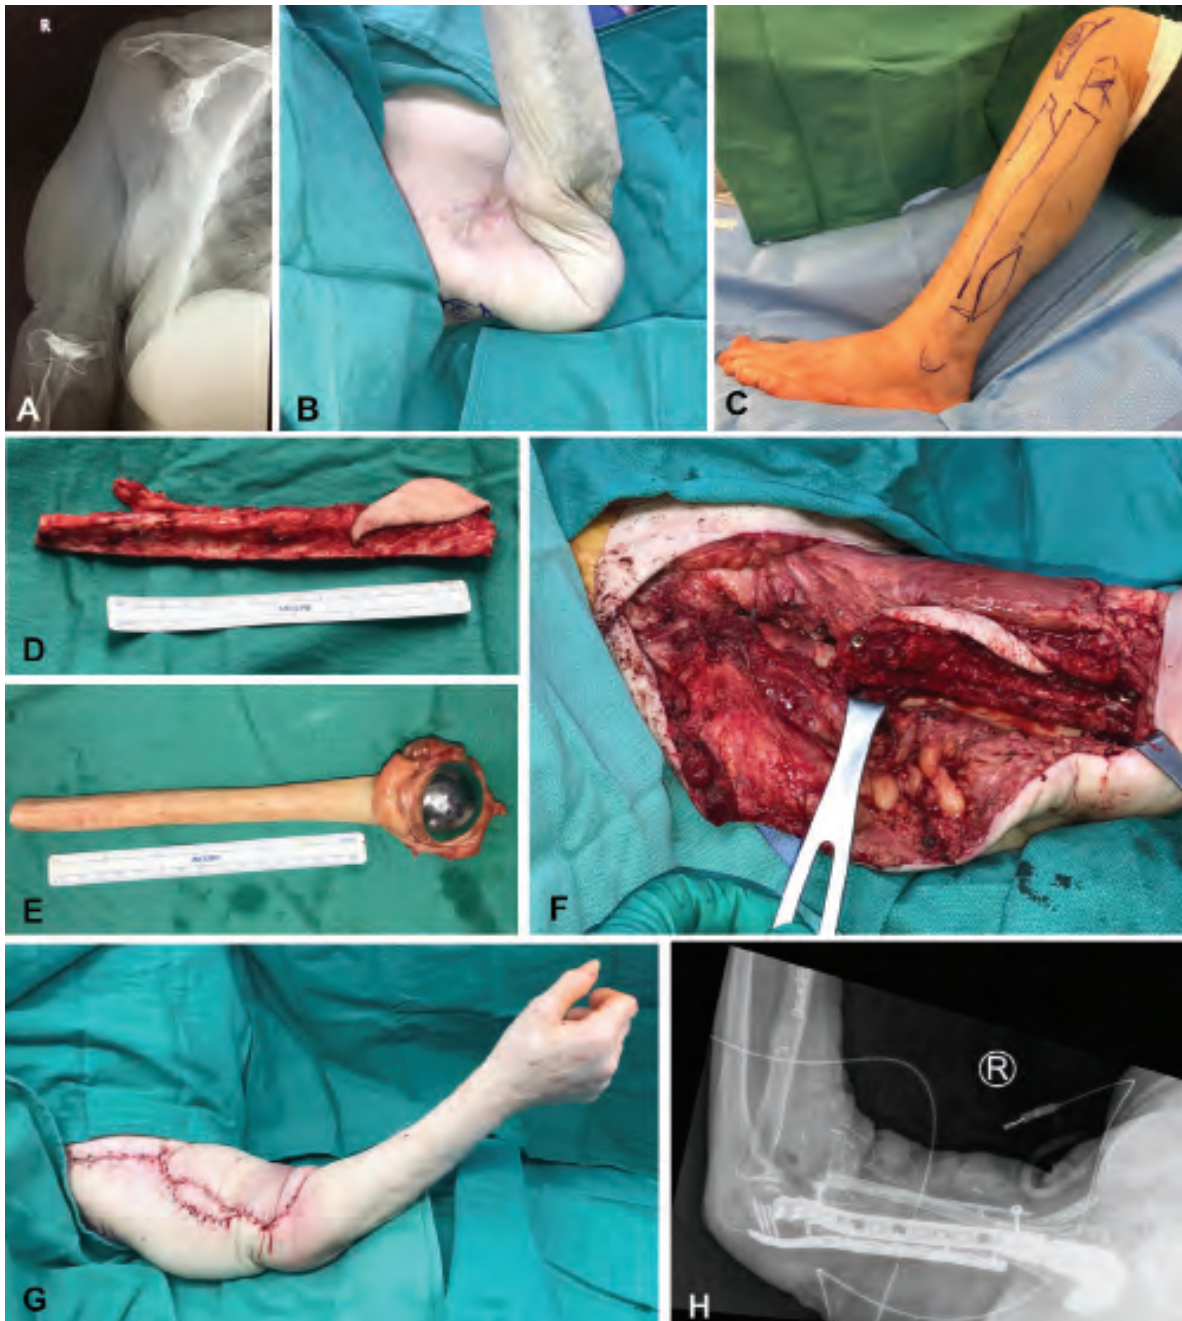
Case 3, Orthoplastic reconstruction of the upper extremity after resection of most of the humerus due to osteomyelitis. Image (A) shows an AP radiograph of the arm missing most of the humerus and (B) shows a clinical photograph of the flail arm. This was reconstructed with a free fibula osteocutaneous flap (C) and (D), combined with a humerus allograft with a hemiarthroplasty (E). Image (F) shows the allograft with the fibula onlay after inseting and the immediate post-operative result (G) and radiograph (H).
